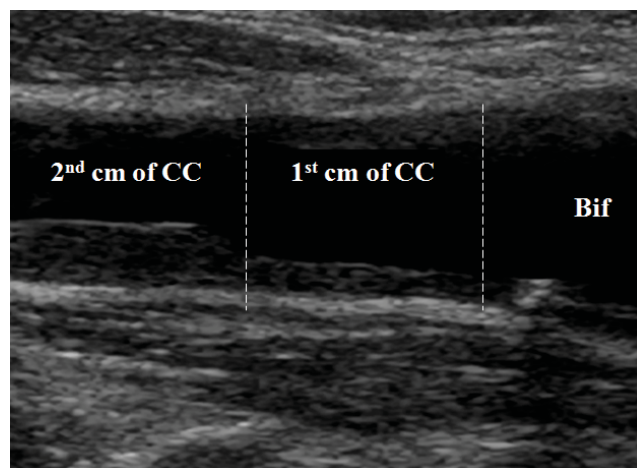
Ultrasonographic image of a common carotid which shows the importance of evaluating the artery in its entire length. Note the chance of underestimation of atherosclerosis burden if only the first distal centimeter of the common carotid artery is considered (as actually is in several clinical and epidemiological studies).
